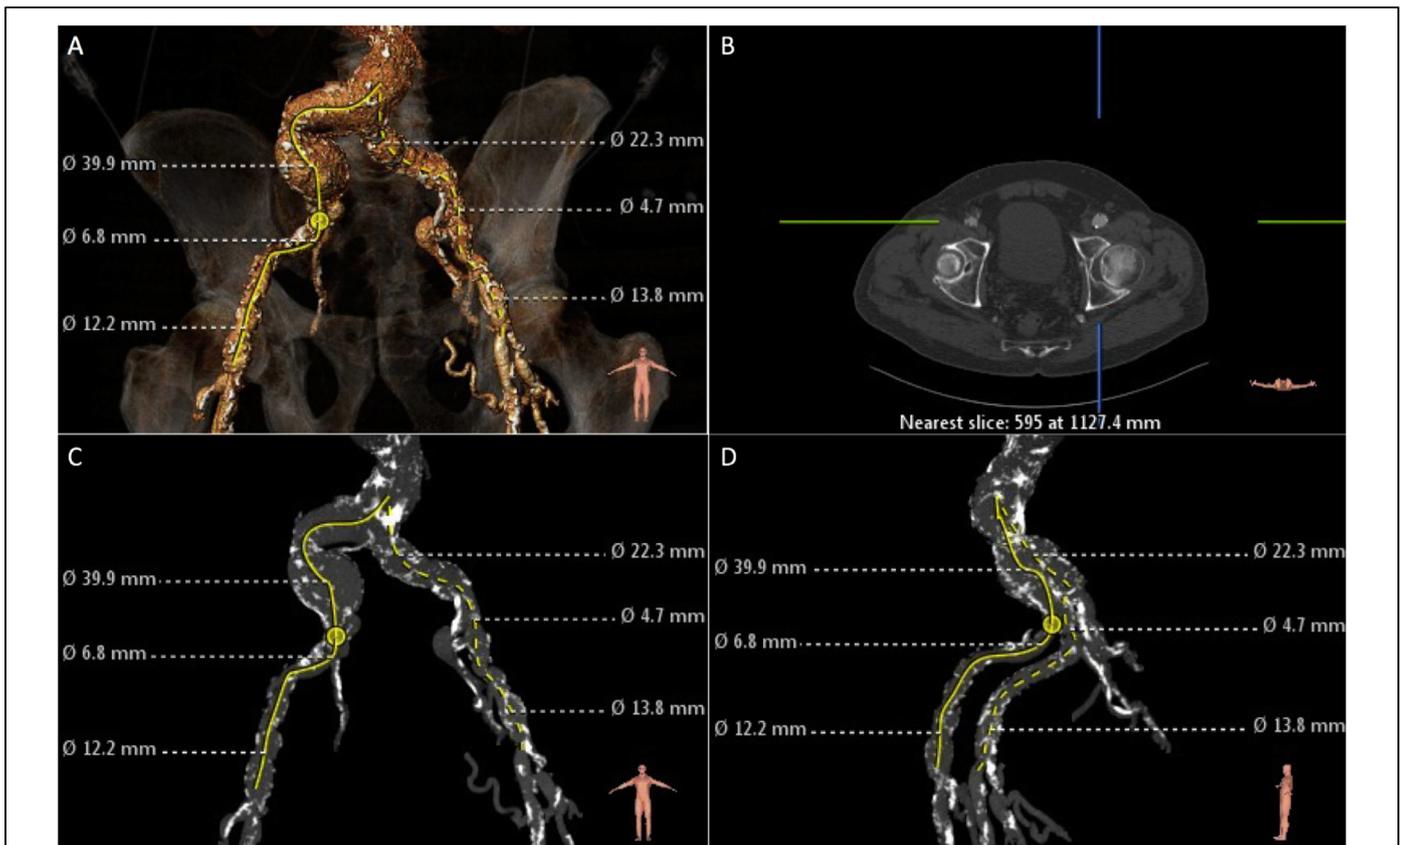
Pre-transcatheter aortic valve implantation computed tomography (CT) images. (A) 3D reconstructed image demonstrating significant tortuosity and aneurysmal segments within the ileo-femoral vessels. (B) An axial cross-sectional image, used to determine the optimal site of access for the left femoral artery. (C and D) 3D reconstructed images demonstrating the extent of calcification within both ileo-femoral arteries.
